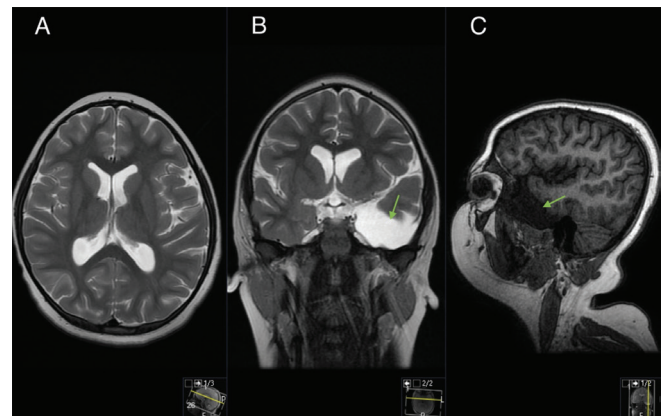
Postoperative magnetic resonance imaging in the axial (A), coronal (B), and sagittal (C) planes. Green arrows: The arachnoid cyst
